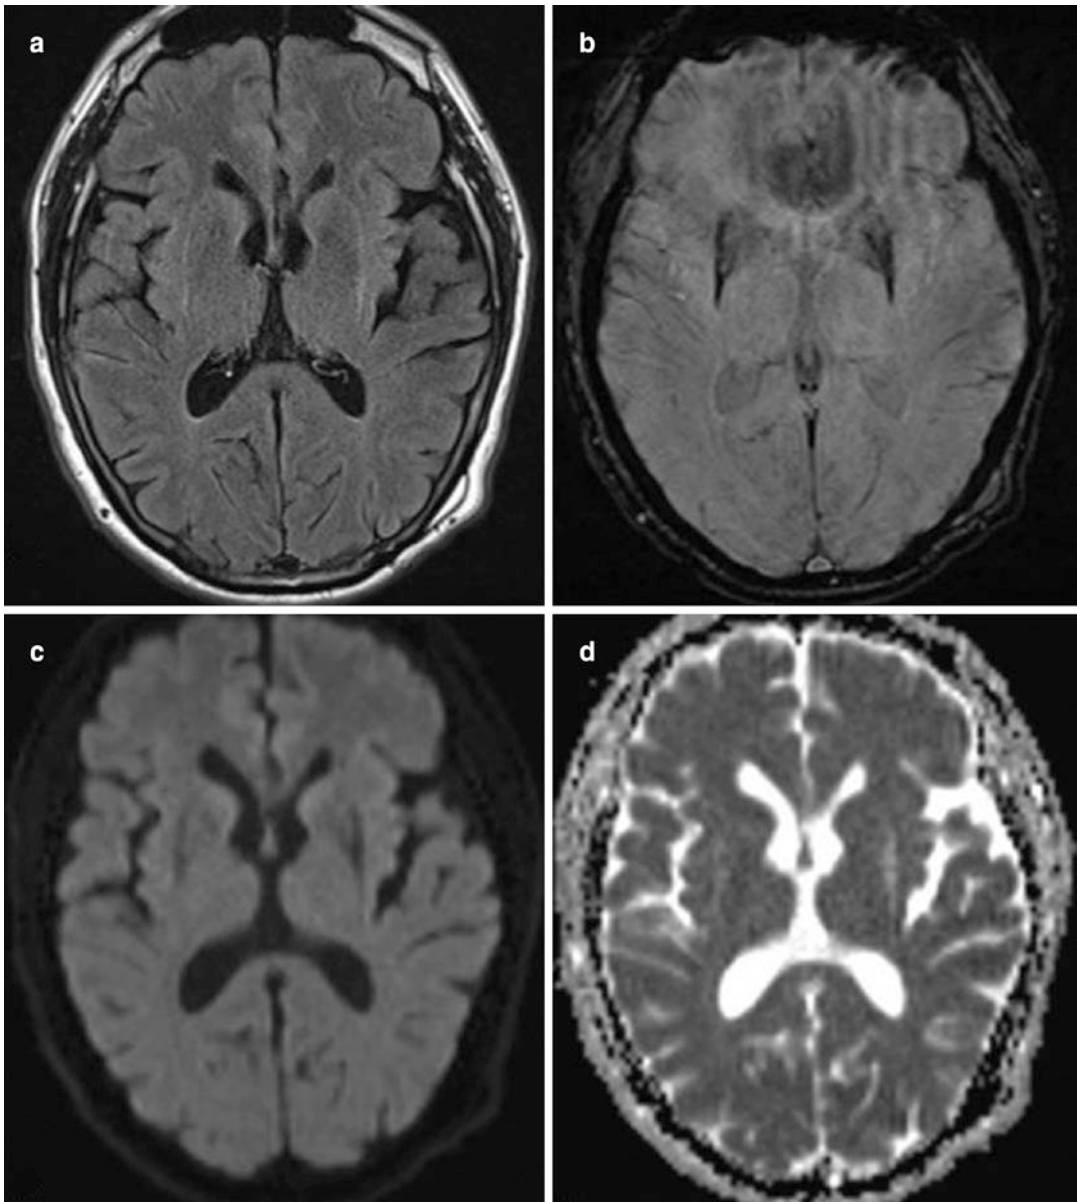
63-year-old man with MSA-P. Diagnosed with parkinsonian syndrome 4 years before without benefit from carbidopa/levodopa. Axial FLAIR (a) and SWI
